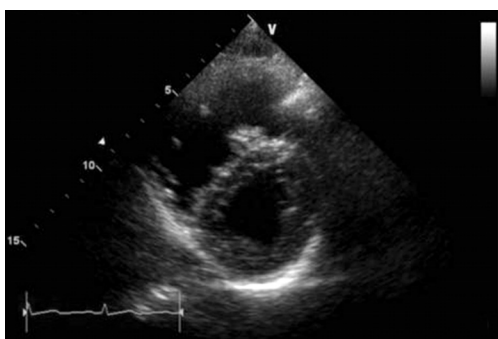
Echocardiography showed enlarged right ventricle and slightly D-shape of left ventricular septum.
